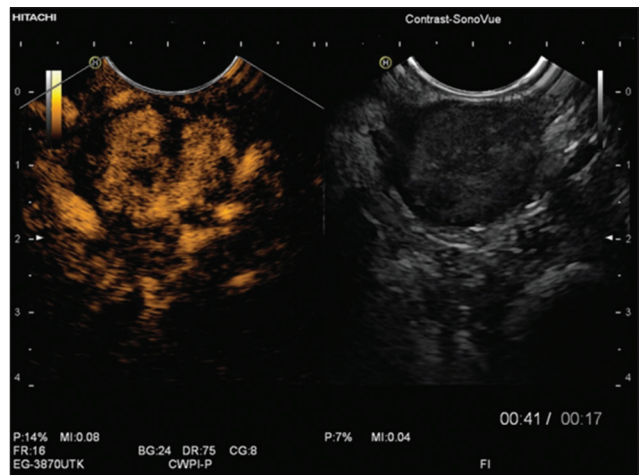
A hyperenhanced gastrointestinal stromal tumor under contrast-enhanced endoscopic ultrasound.^[7] An avascular area is located in the center
